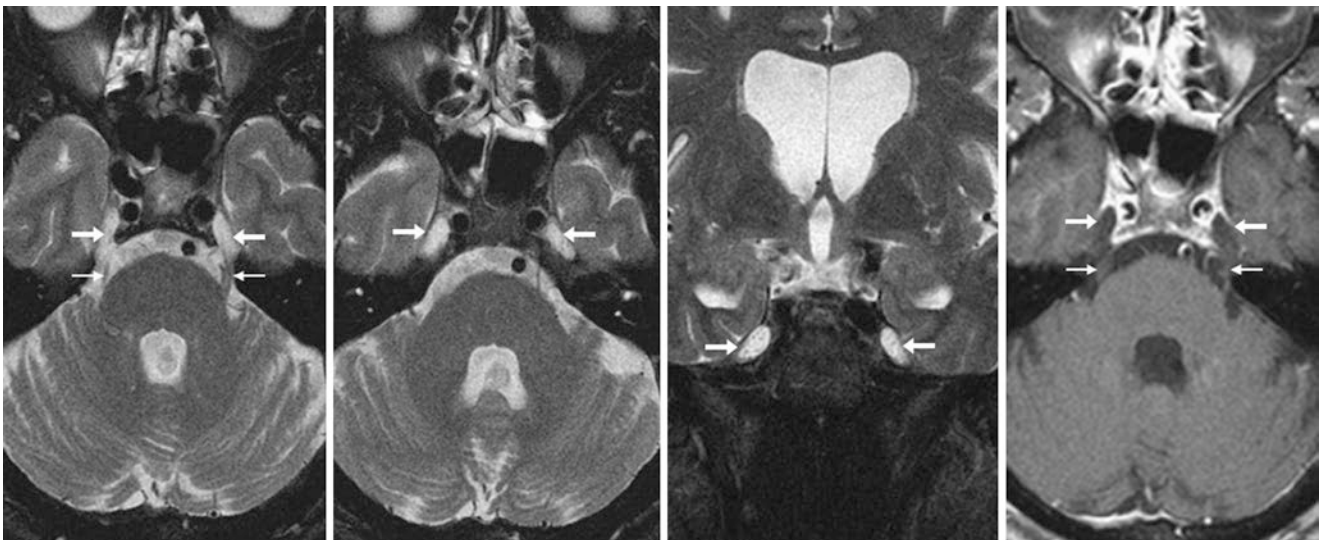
A 62-year-old patient with migraines presented for MRI (negative). Axial T2WIs (*left and left middle*) demonstrate mildly prominent subarachnoid spaces extending into Meckel caves bilaterally (*arrows*). These appear normal on coronal T2WI (*right middle*) and postcontrast
